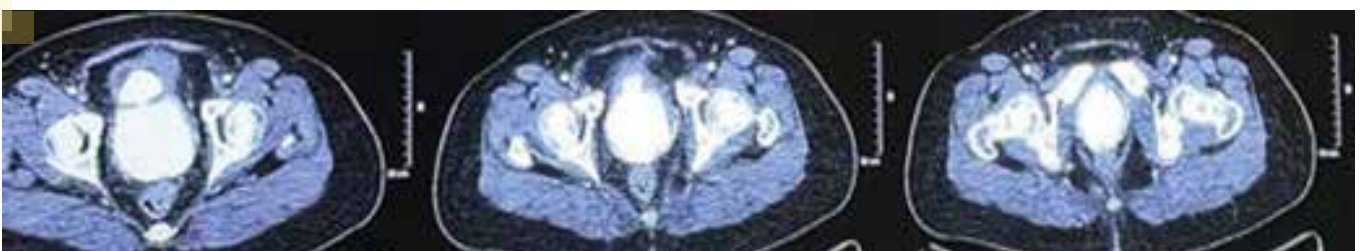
Plain CT (part of PET CT) showing a large vaginal stone with a dumbbell-shaped component inside the bladder
